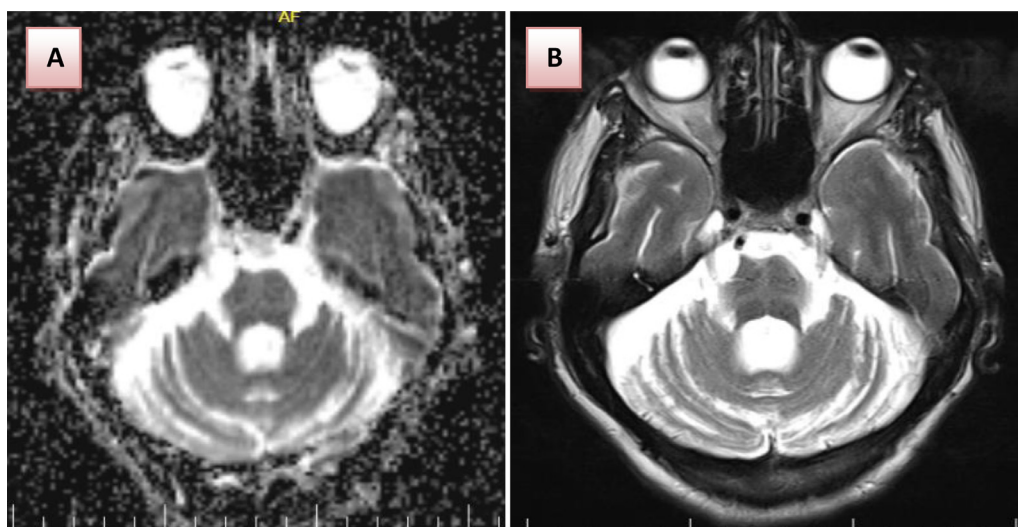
Apparent diffusion coefficient (ADC) and T2 sequence of magnetic resonance imaging shows atrophy of the pons and cerebellum (A, B).
